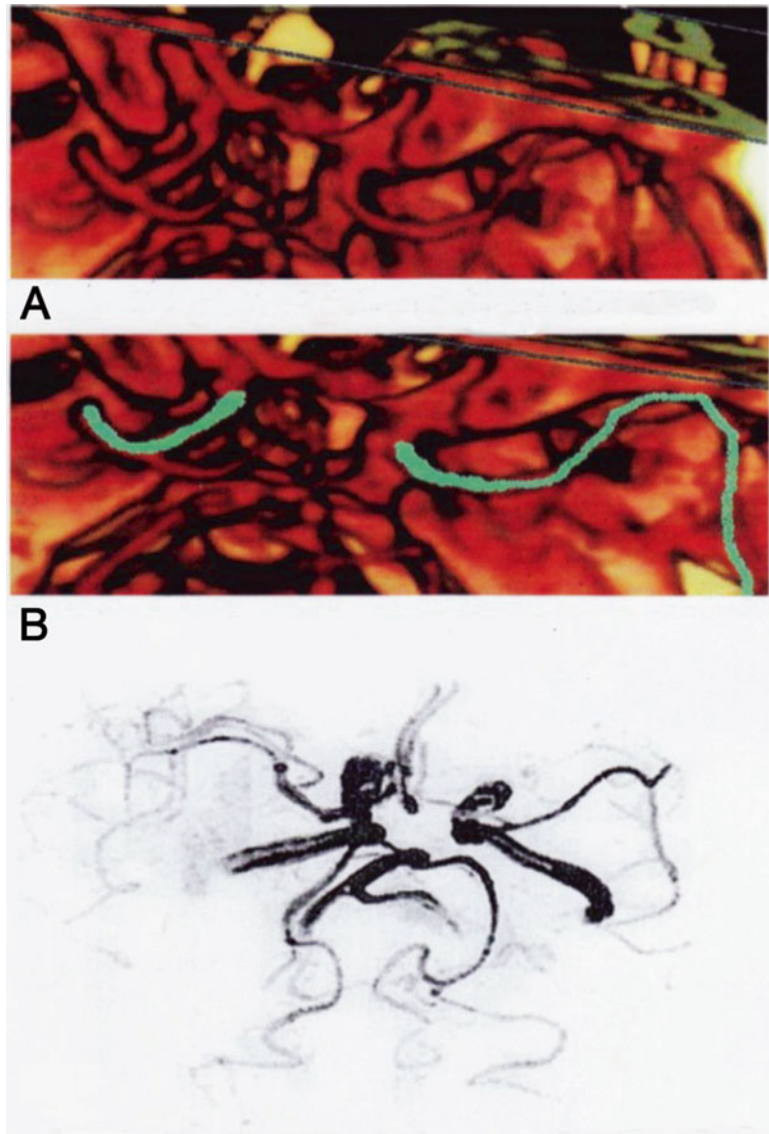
Case example: acute stroke management in the elderly with use of tPA. An 88-year-old female who becomes aphasic and falls into the arms of her husband in her kitchen with a sudden right-sided paralysis; CT head exam obtained later in ED was negative for hemorrhage (Fig. 3.38)
